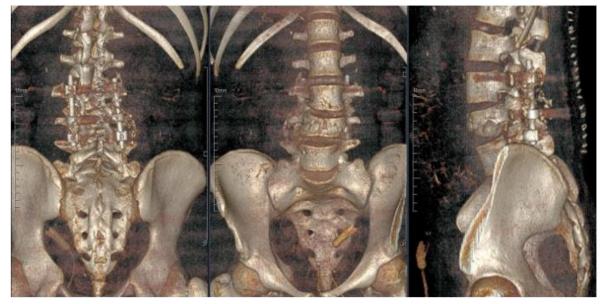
Postoperative Multislice 3D CT scan images (posterior, anterior and lateral views respectively) showing posterior L3 and L5 fixation and laminectomy of L4 and proper placement of the polyaxial screws with no loosening.
